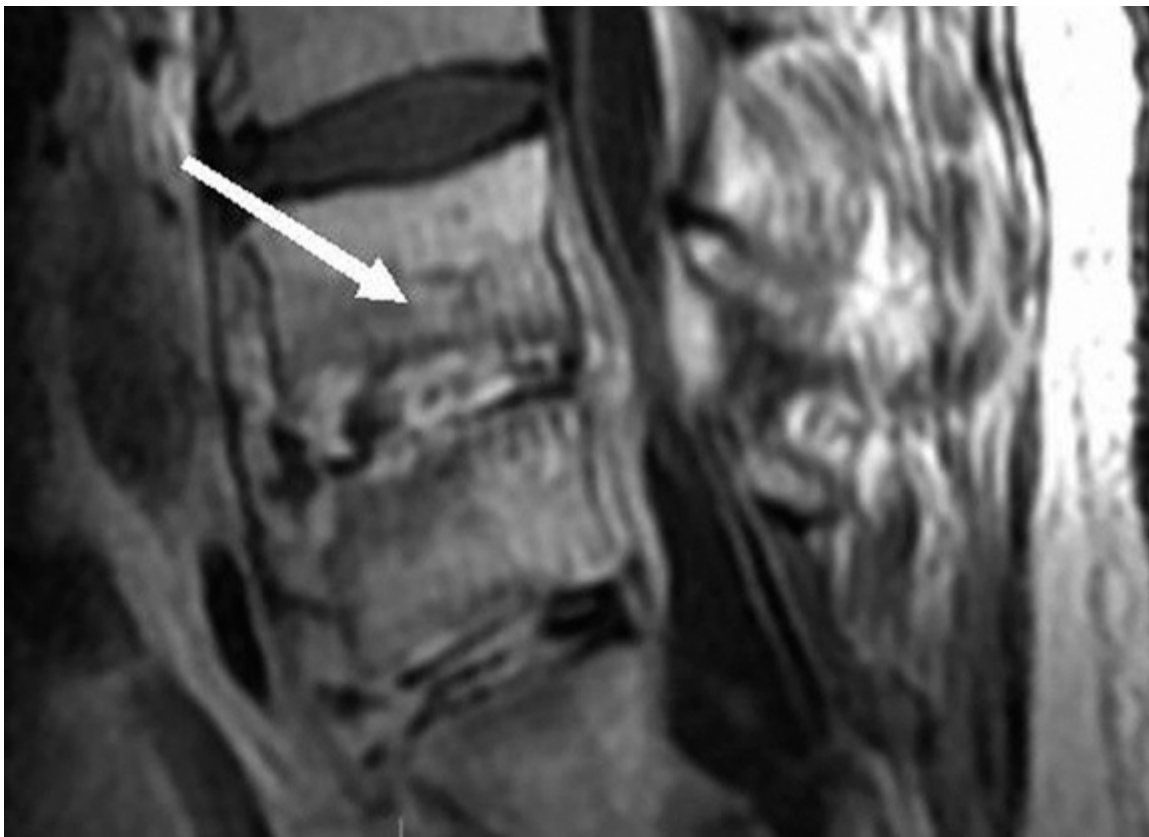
Sagittal magnetic resonance T1-weighted image with contrast of the lumbar spine demonstrating diskitis or osteomyelitis associated with a spinal epidural abscess. (Reproduced, with permission, from Doherty GM. *Current Diagnosis & Treatment: Surgery*. 13th ed. New York: McGraw-Hill; 2010.)
